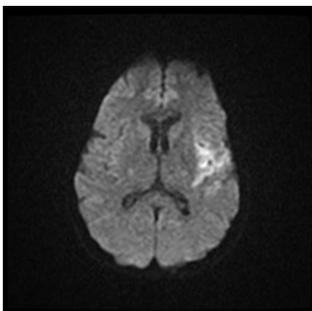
Diffusion MRI before thrombolysis with a diffusion abnormality in the parietotemporal lobe less than 1/3 of the MCA territory
